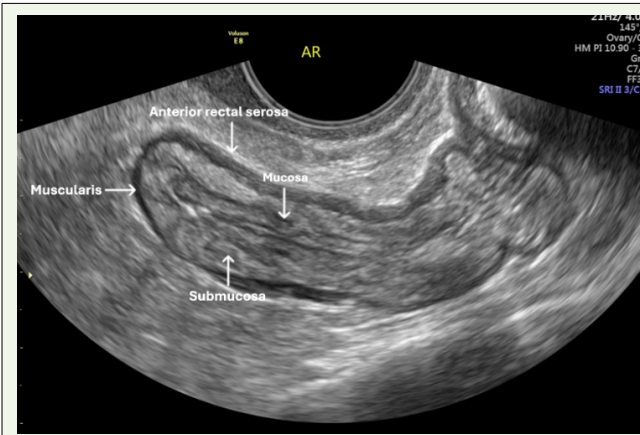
Anatomy of the bowel wall on ultrasound.
